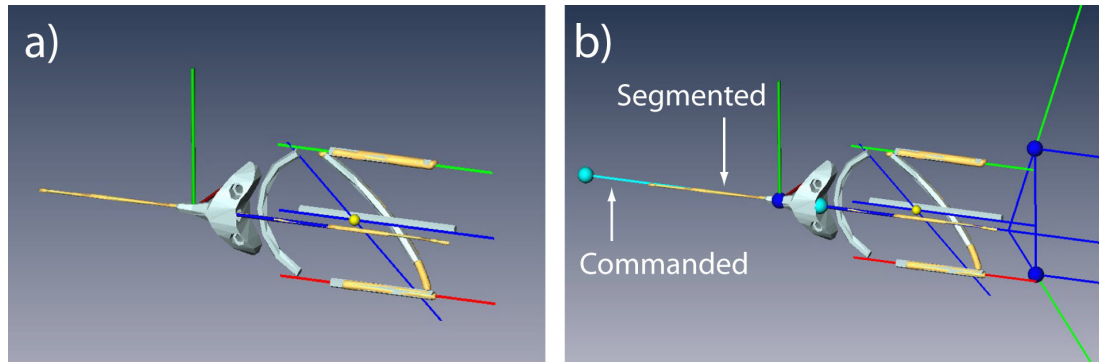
CT-guided reversed targeting
